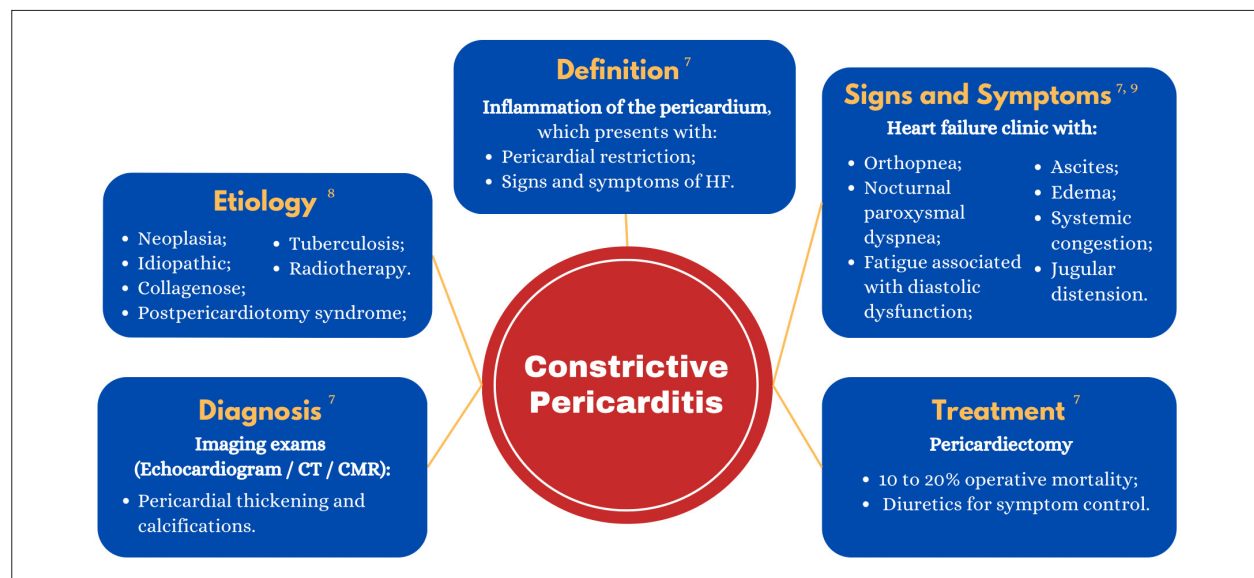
Features of constrictive pericarditis. HF: heart failure; CT: computed tomography; CMR: cardiac magnetic resonance.
